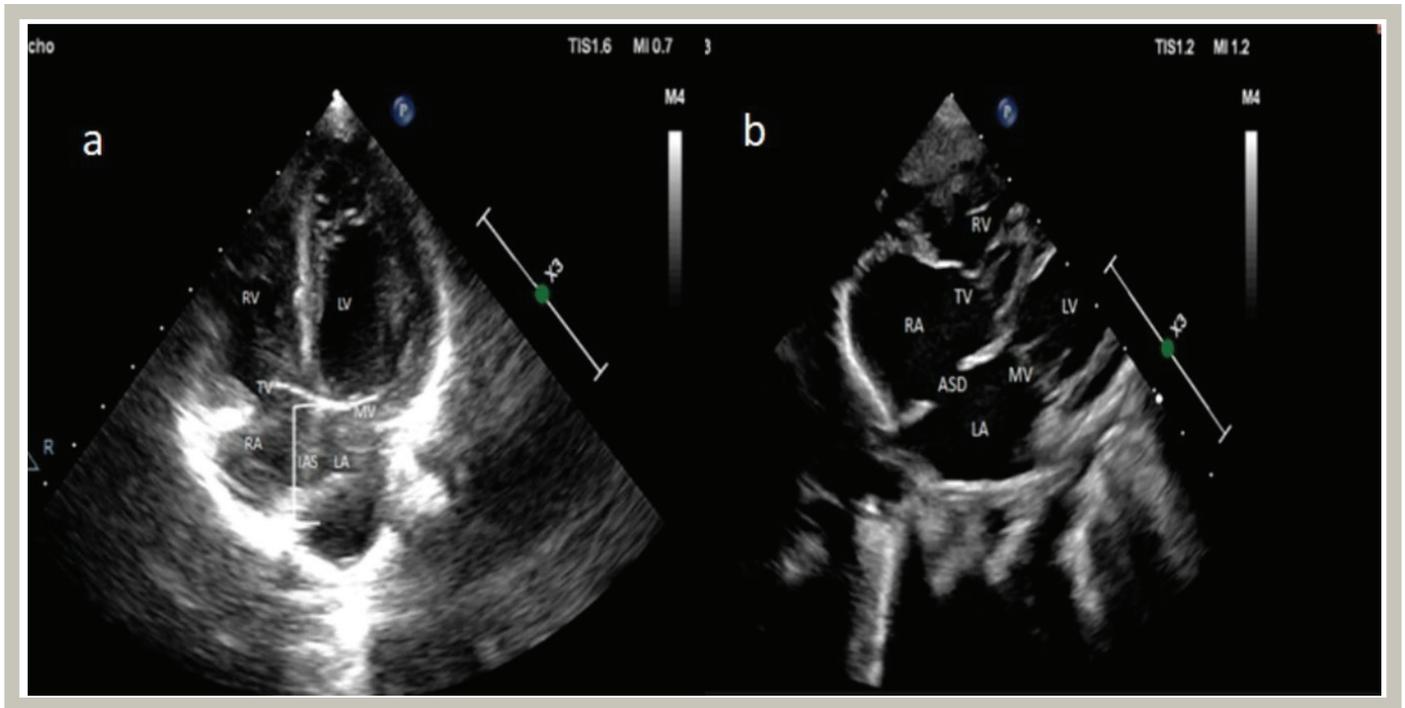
Ten days old male patient with transposition of the great arteries. a) Modified four chamber view on echocardiographic examination, b) modified subcostal chamber view on echocardiographic examination
